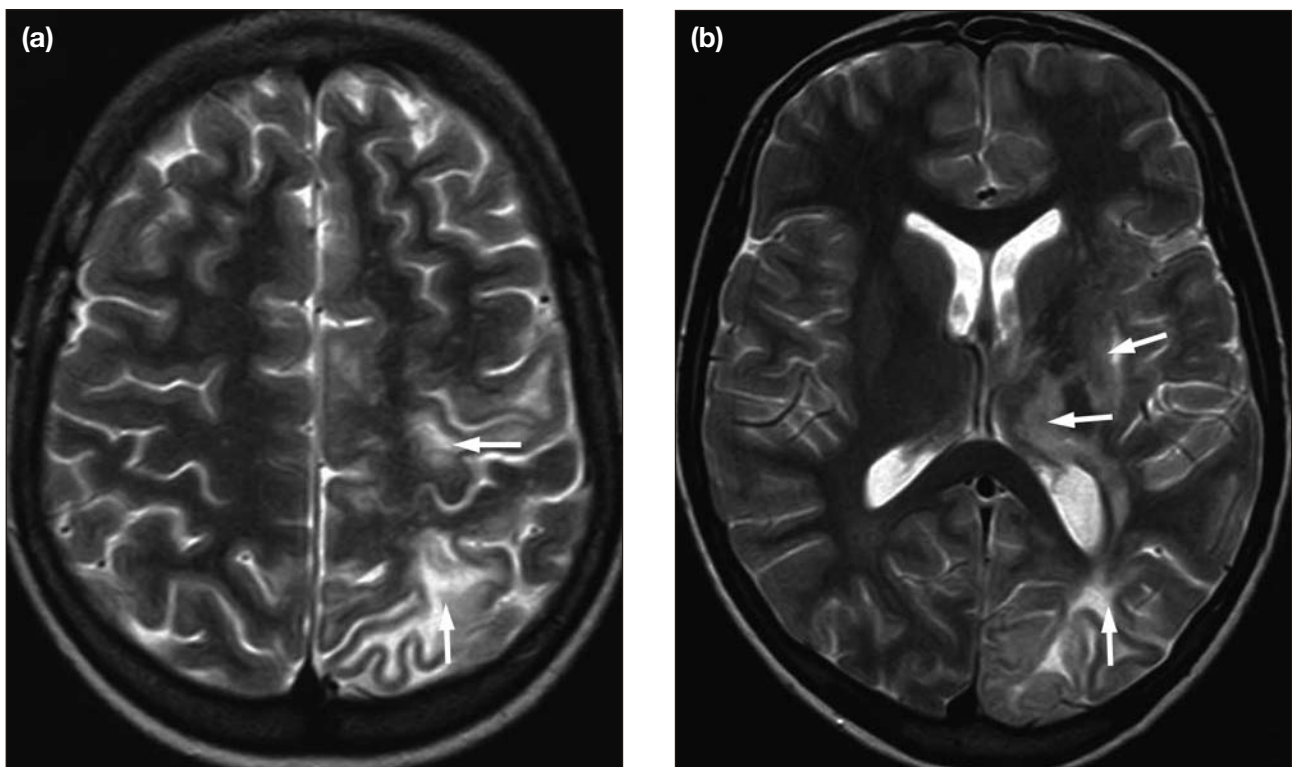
Axial T2-weighted magnetic resonance images of the brain at presentation showing focal T2-hyperintense areas in (a) the left parieto-occipital and precentral white matter (arrows); and (b) the left thalamus and basal ganglia (arrows).
